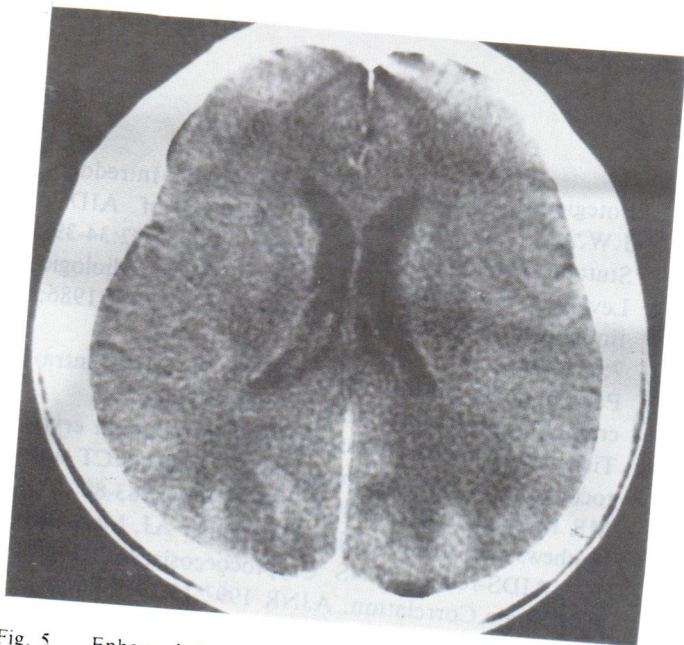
Enhanced CT scan showed low density of white matter of both parieto-occipital lobes without enhanced nidus, in tuberculosis.
